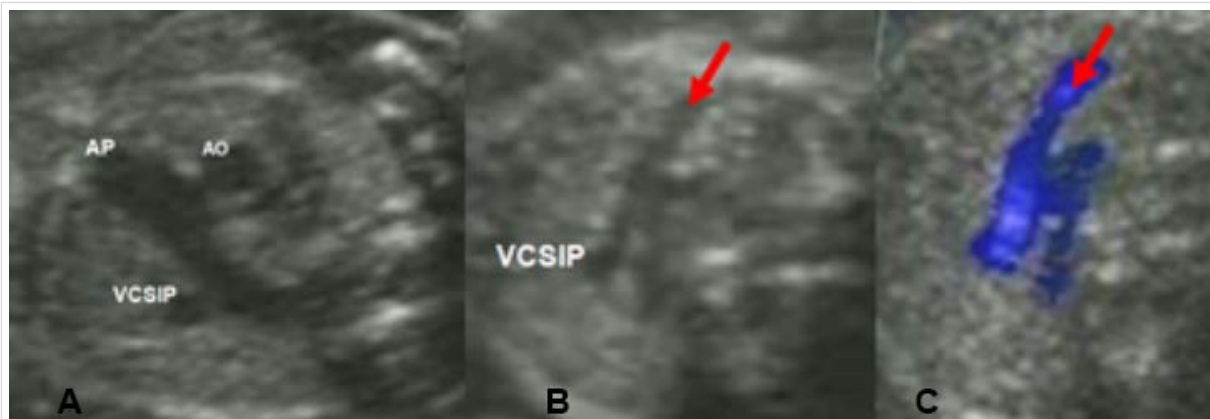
A. Three-vessel echocardiographic view. From left to right: left superior vena cava (VCSIP), pulmonary (AP) and aorta (AO) arteries. B. Transverse echocardiographic view (anterior) showing the innominate vein (arrow) entering the left superior vena cava (VCSIP). C. Color overlay on the two-dimensional image reveals the color flow path (blue) from right to left, characteristic of cases with absent right superior vena cava.
